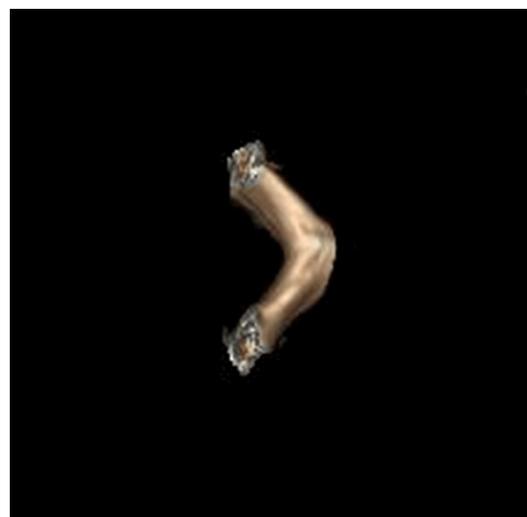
The 3D reconstruction CT of the cervical laminae, which was used as a bone graft in ACDF.
